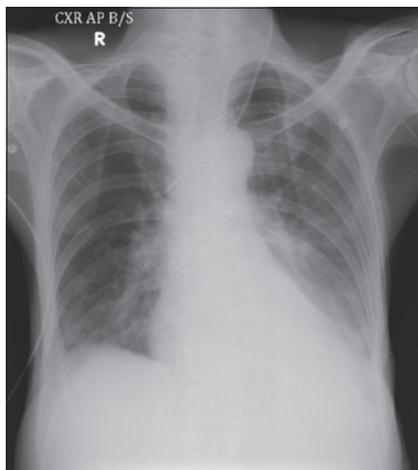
X-ray at time of discharge from intensive care units
